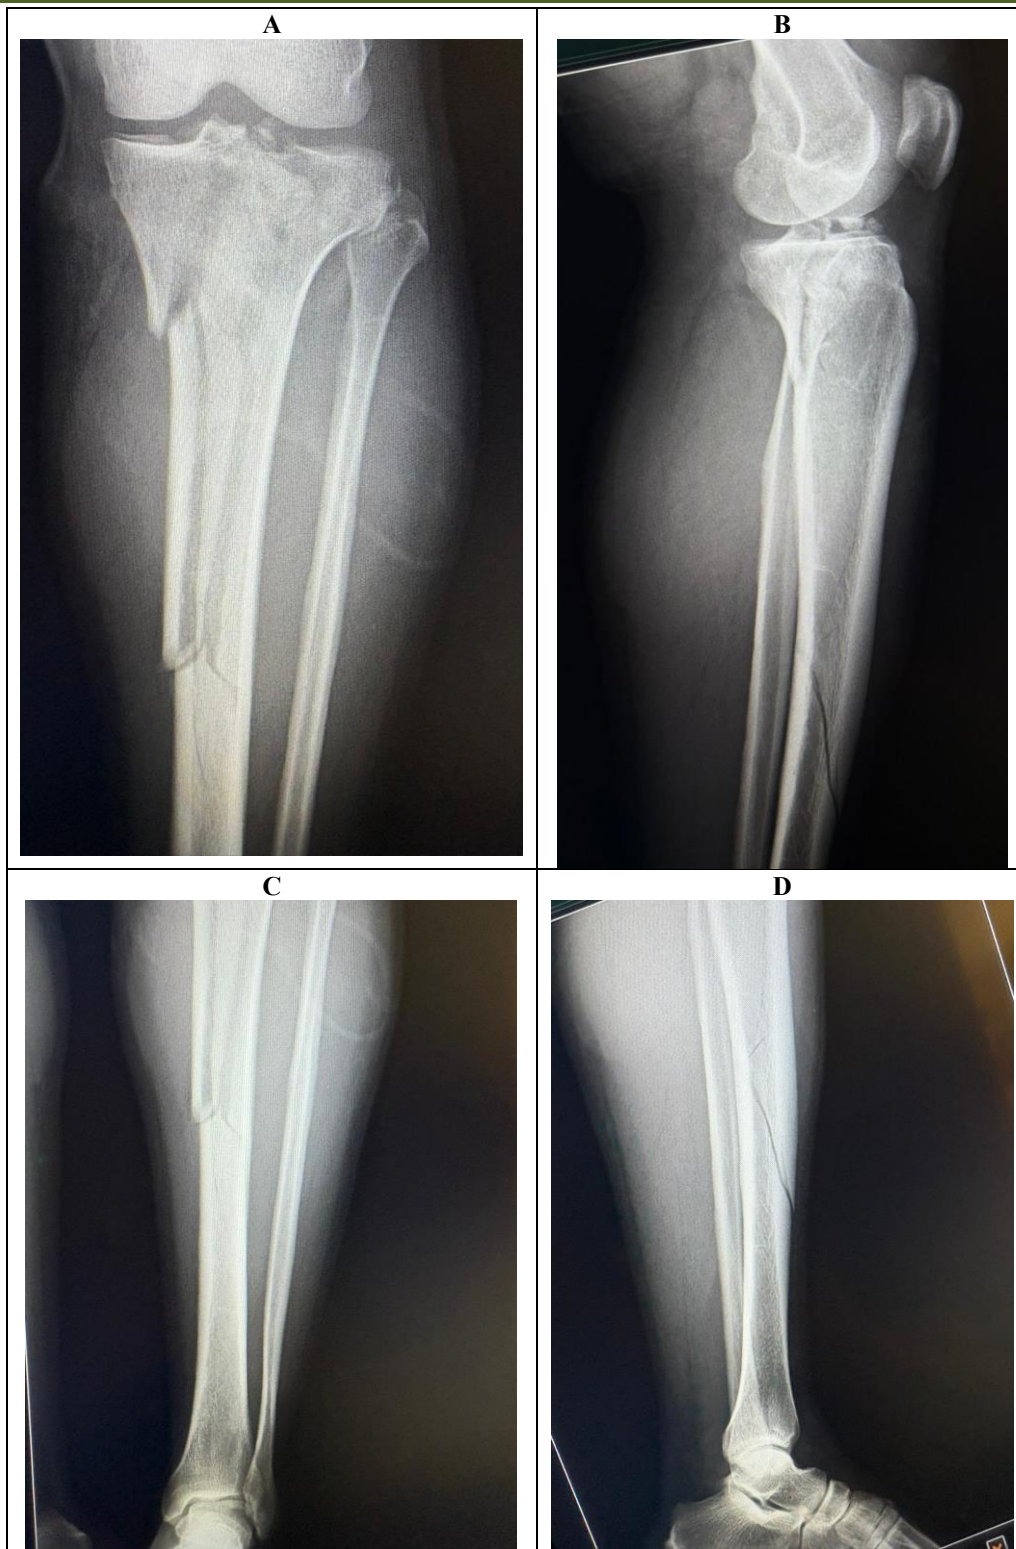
Preoperative radiographs. (A) Anteroposterior view centred on the knee and proximal tibia. (B) Lateral view. (C-D) Anteroposterior and lateral views of the leg showing diaphyseal extension. The pattern is consistent with a bicondylar tibial plateau fracture with metaphyseal-diaphyseal dissociation, Schatzker type VI
